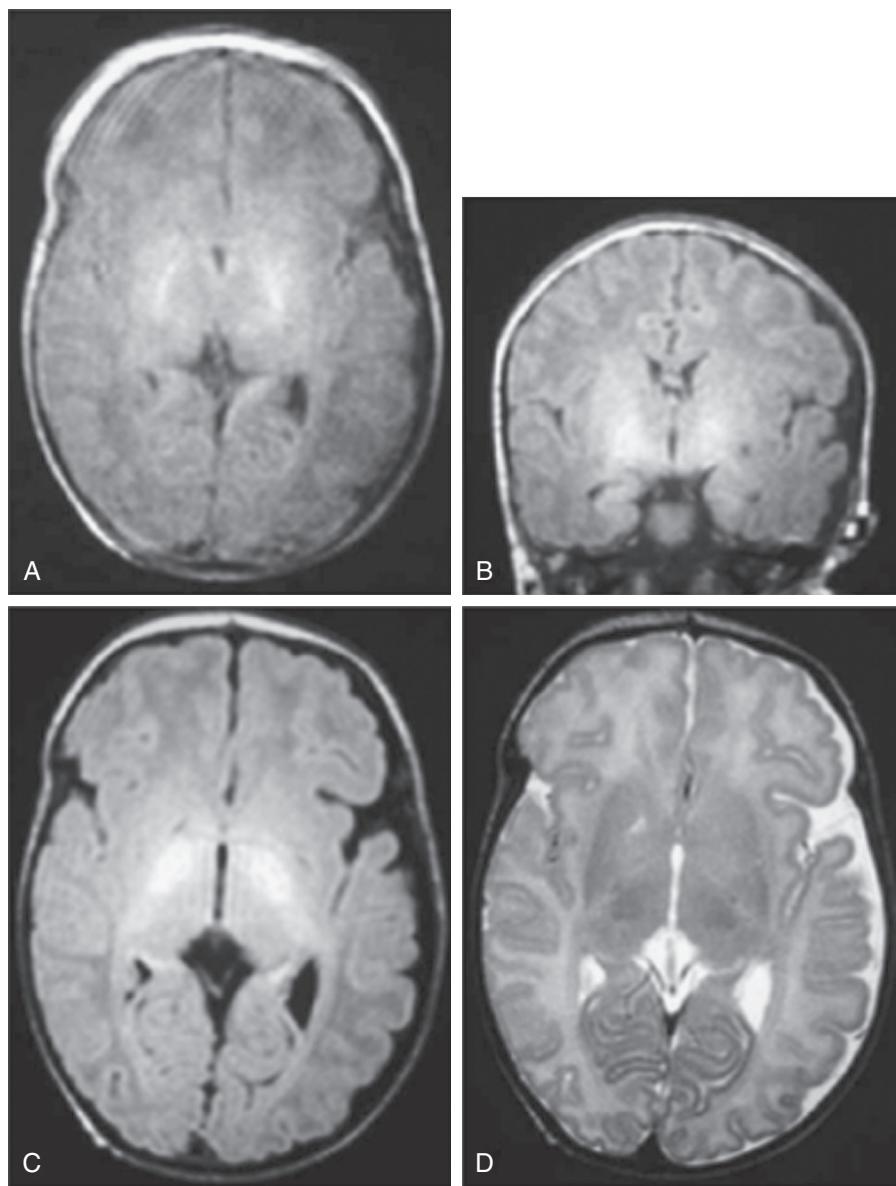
Magnetic resonance images of a 21-day-old, preterm male neonate with acute kernicterus. Axial (A) and coronal (B) T1-weighted and axial FLAIR (C) images at the level of the basal ganglia show symmetric, hyperintense globus pallidus involvement. This is not apparent on the axial T2-weighted (D) image. (From Coskun A, et al. Hyperintense globus pallidus on T1-weighted MR imaging in acute kernicterus: is it common or rare? *Eur Radiol*. 2005;15:1263.)
